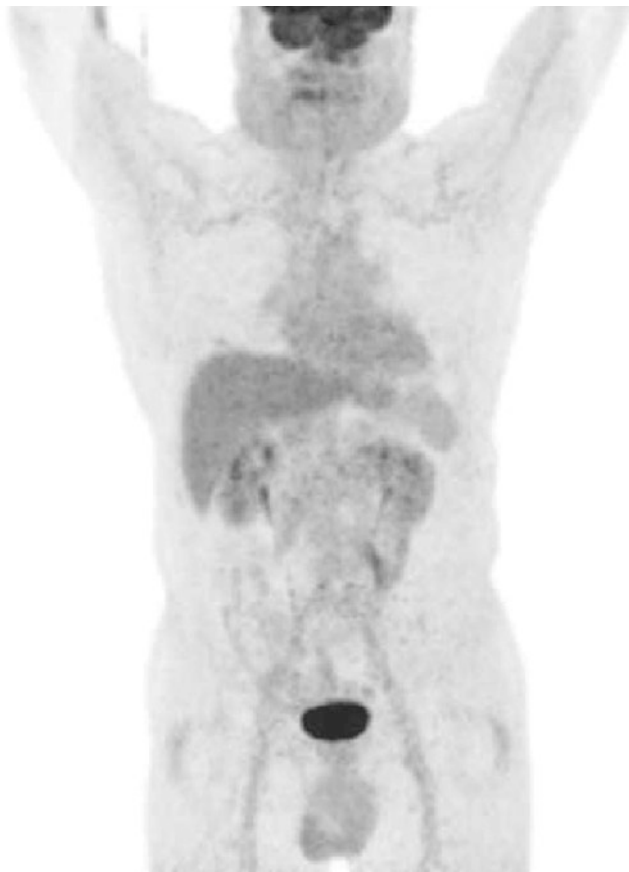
PET/CT MIP image obtained 60 min after [^{18}F]FDG injection shows the physiologic pattern of biodistribution of this metabolic tracer
